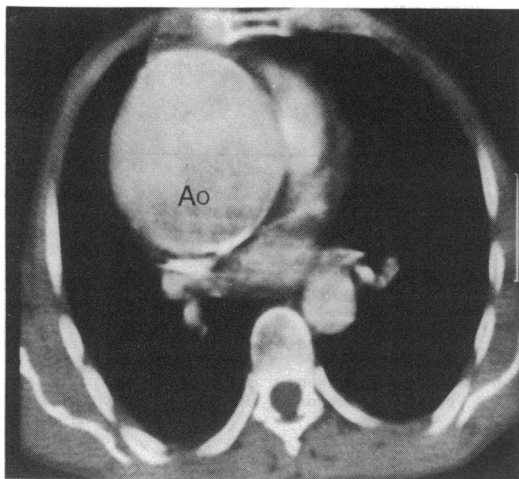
A contrast enhanced computed tomograph in case 60 confirming the results of an echocardiogram which showed severe aneurysm of ascending aorta and excluded dissection. Aortic calcifications are evident. Ao, aorta.
